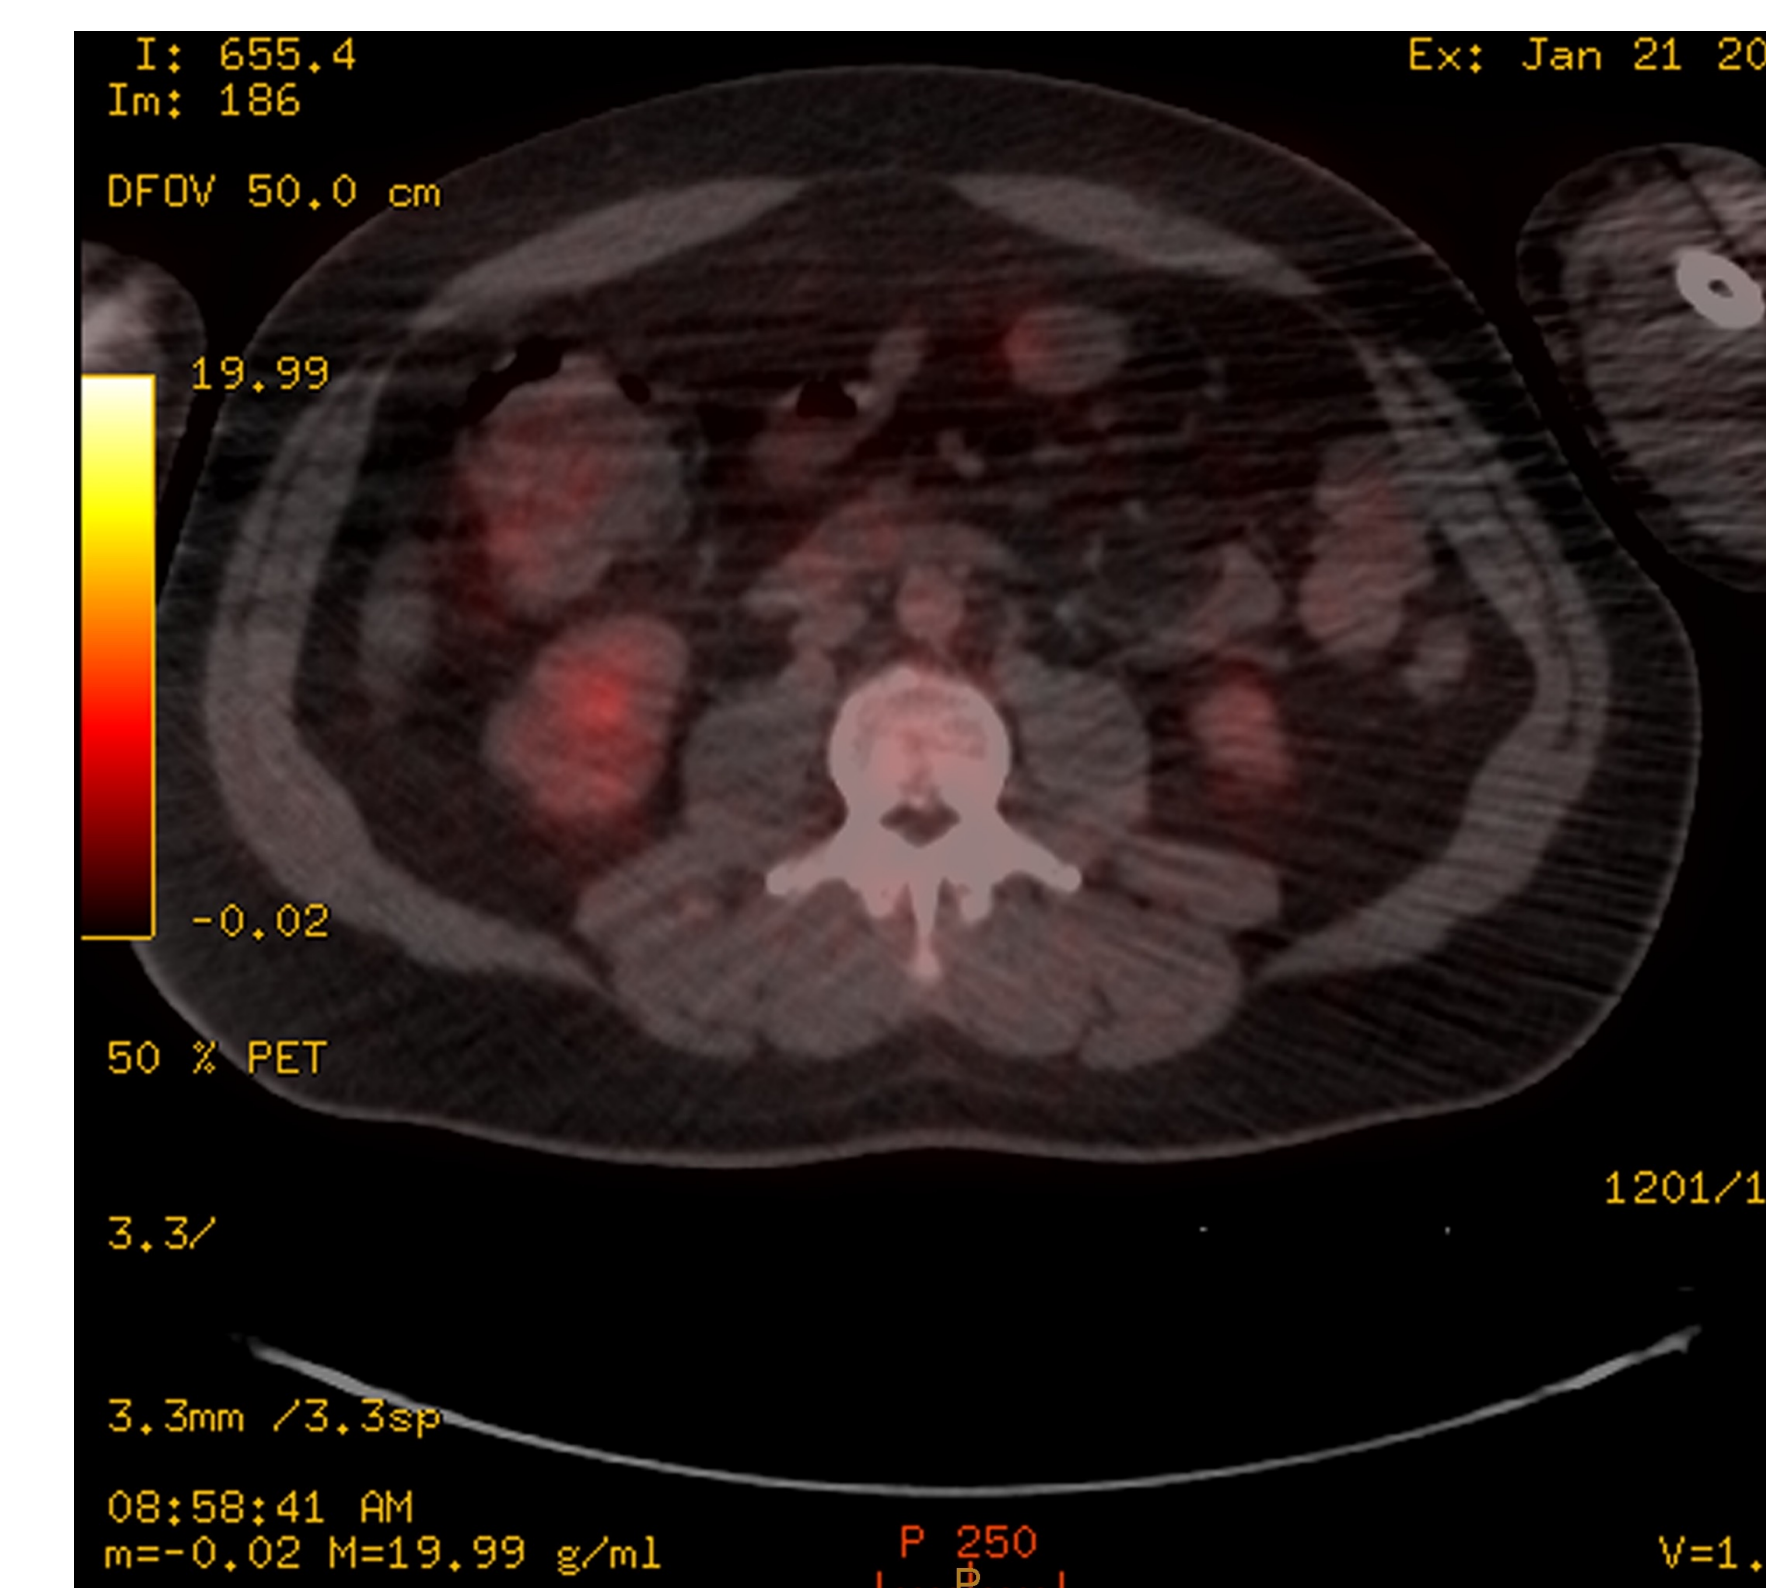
PET-CT image of mass in hepatic flexure without FDG uptake.
